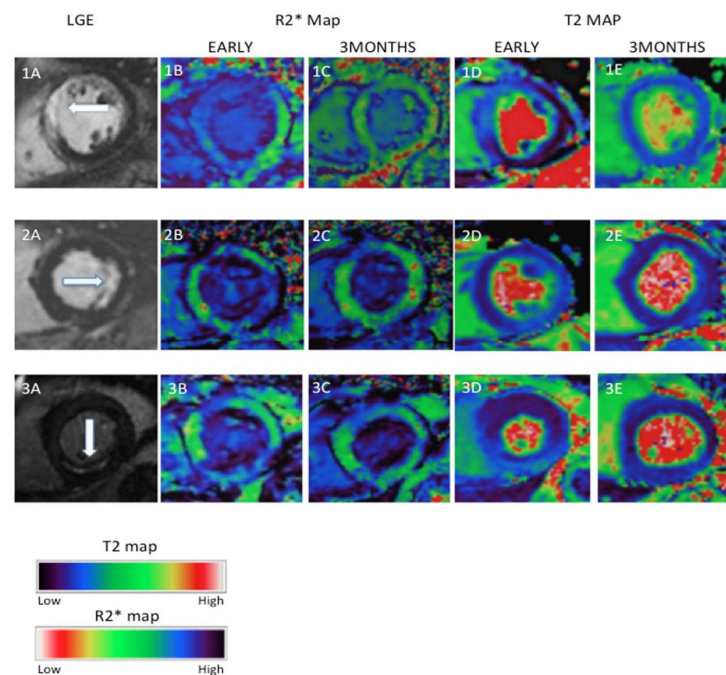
Examples of myocardial oedema and ferumoxytol enhancement in the infarct area after myocardial infarction (MI). Three examples of MI (1, anteroseptal, 2, lateral and 3, inferior) showing LGE on T1-weighted imaging (1A–3A), ferumoxytol enhancement ($R2^*$ maps) (1B–3B,1C–3C), and oedema (T2 maps) (1D–3D,1E–3E) at early (up to 10 days in (1B–3B,1D–3D)) and late (3 months in (1C–3C,1E–3E)) post-MI. Early inflammation and oedema seen on $R2^*$ maps (dark region) and T2 maps (light region), respectively, have improved or resolved by three months [31]. Reproduced with permission from Stirrat et al. [31] under a Creative Commons Attribution 4.0 International License.
